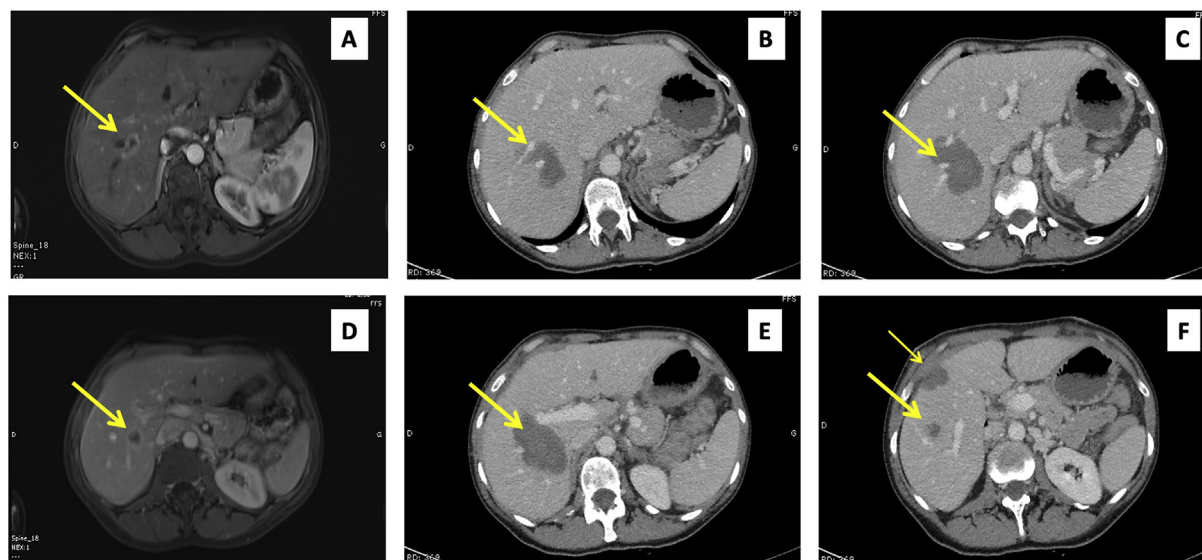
A: Preoperative MRI gadolinium-enhanced T1-weighted sequence: 15mm nodule (yellow arrow) next to origin of right hepatic vein. B/C: Postoperative day 7 CT scan showing ablation area with perfect patency of origin branches of right hepatic vein. D: Preoperative MRI gadolinium-enhanced T1-weighted sequence: 20mm nodule (yellow arrow) next to portal branch of the right posterior sector. E/F: On postoperative day 7 CT scan, large ablation area without signs of vascular complication.
